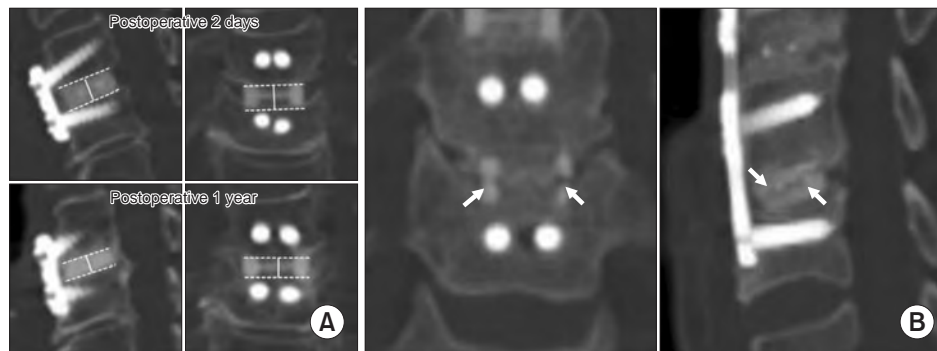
Allograft resorption and fracture in anterior cervical discectomy and fusion. (A) Allograft resorption was assessed when there was a height difference of ≥ 1 mm in 1-year postoperative computed tomography (CT) scan. (B) Graft fracture was assessed when the fracture line at the cortical portion of the allograft was detected on the 1-year postoperative CT scan (arrows).
